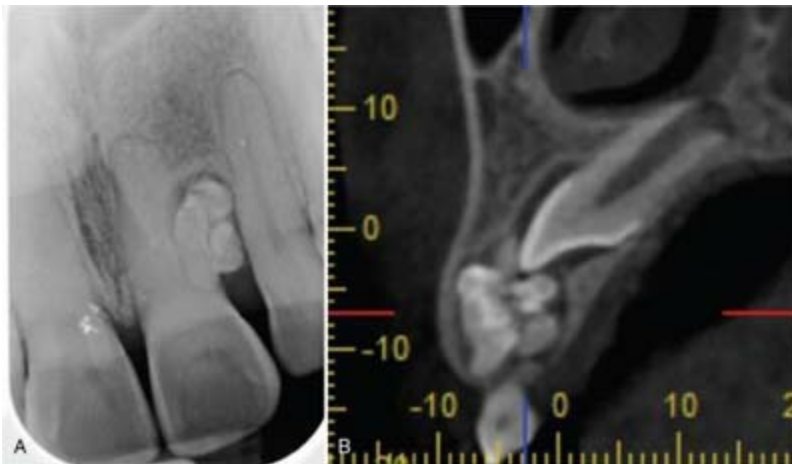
A, Periapical image of a compound odontoma in a 35-year-old female. Multiple radiopacities resembling teeth are located interproximal to the maxillary central and lateral incisors. B, CBCT image demonstrating multiple high-density toothlike structures in association with a corticated low-density zone resembling dental follicle.
